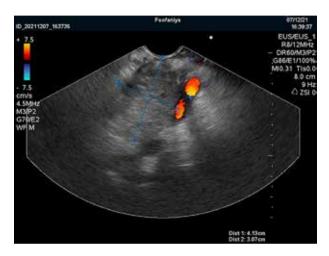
Endoscopic ultrasonography. One of the scans of the pancreatic tumor, the splenic vein is visible on the right, to which the tumor with an uneven vessel contour is closely adjacent, indicating invasion. The tumor has an uneven parenchyma, mostly hypoechoic with separate hyperechoic loci and anechoic tubular structures, which are probably the remains of partial ducts
